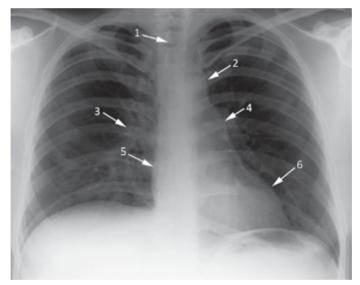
Normal landmarks on posteroanterior chest X-ray. 1 – trachea; 2 – aortic knuckle formed by the aortic arch; 3 - right hilum; 4 - left hilum; 5 - pulmonary artery; 6 - left atrium
